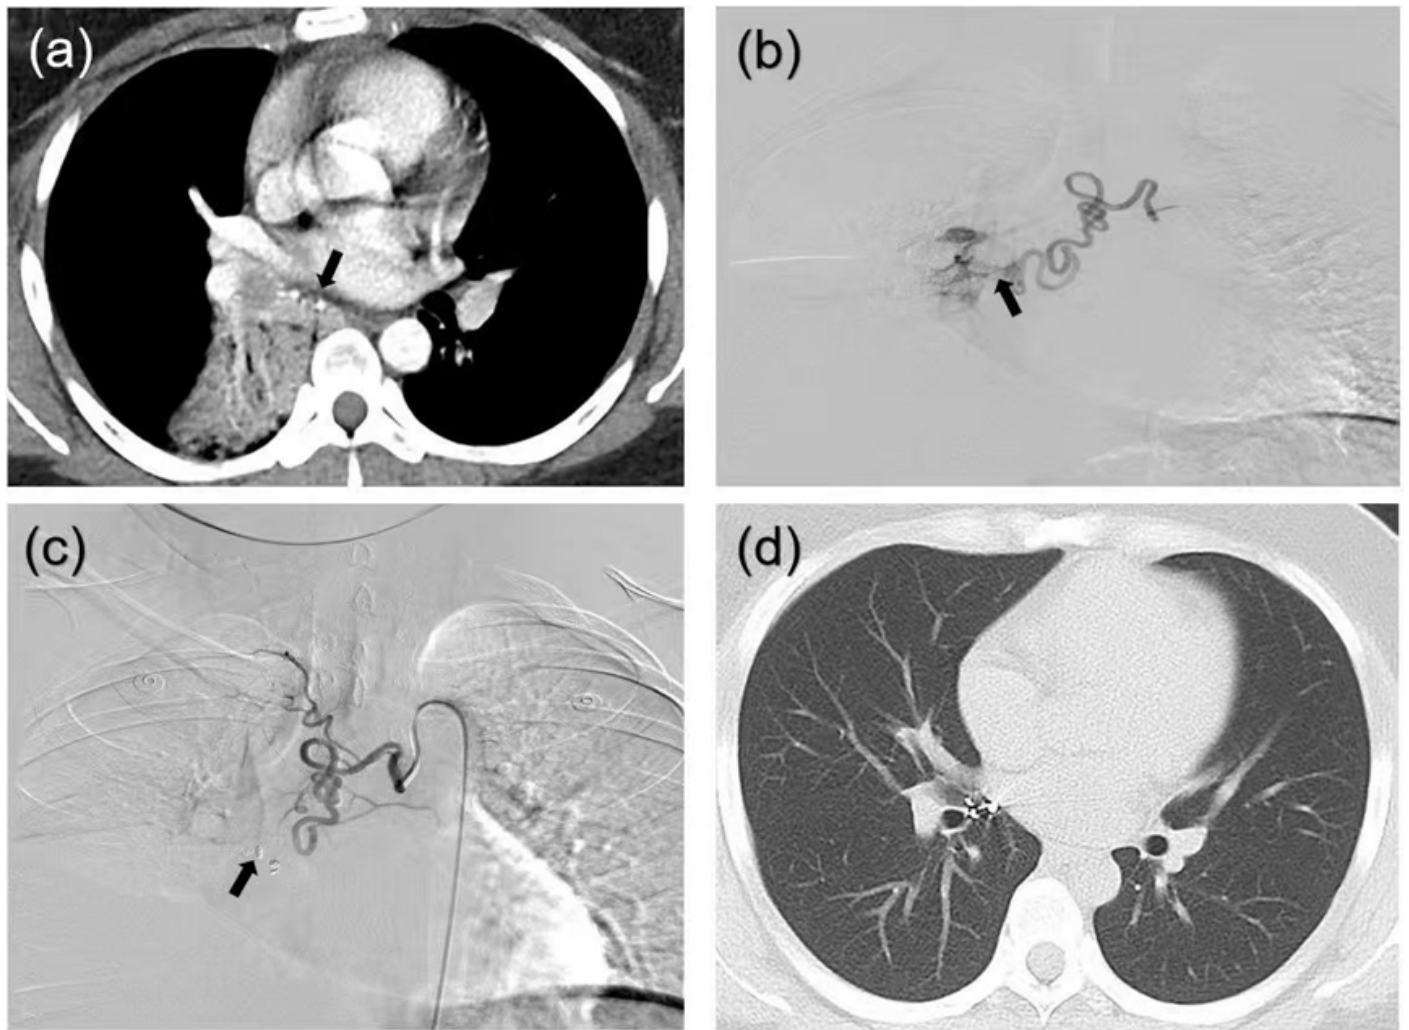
BAE treatment for RHBA. (A) Initial contrast-enhanced thoracic CT: Origin of RHBA from thoracic aorta. Consolidation with bronchial obstruction in right middle and lower lobes. (B) DSA: Tortuous and dilated RHBA with active contrast extravasation. Plexiform vascular network at rupture site. (C) Post-embolization angiography: Successful distal coil embolization of culprit vessel. Complete resolution of abnormal vascular blush. (D) 5-month follow-up non-contrast CT: Complete resolution of bilateral pulmonary patchy opacities. Punctate hyperdensities at right hilum (consistent with embolic material). Satisfactory re-expansion of right middle and lower lobes.
